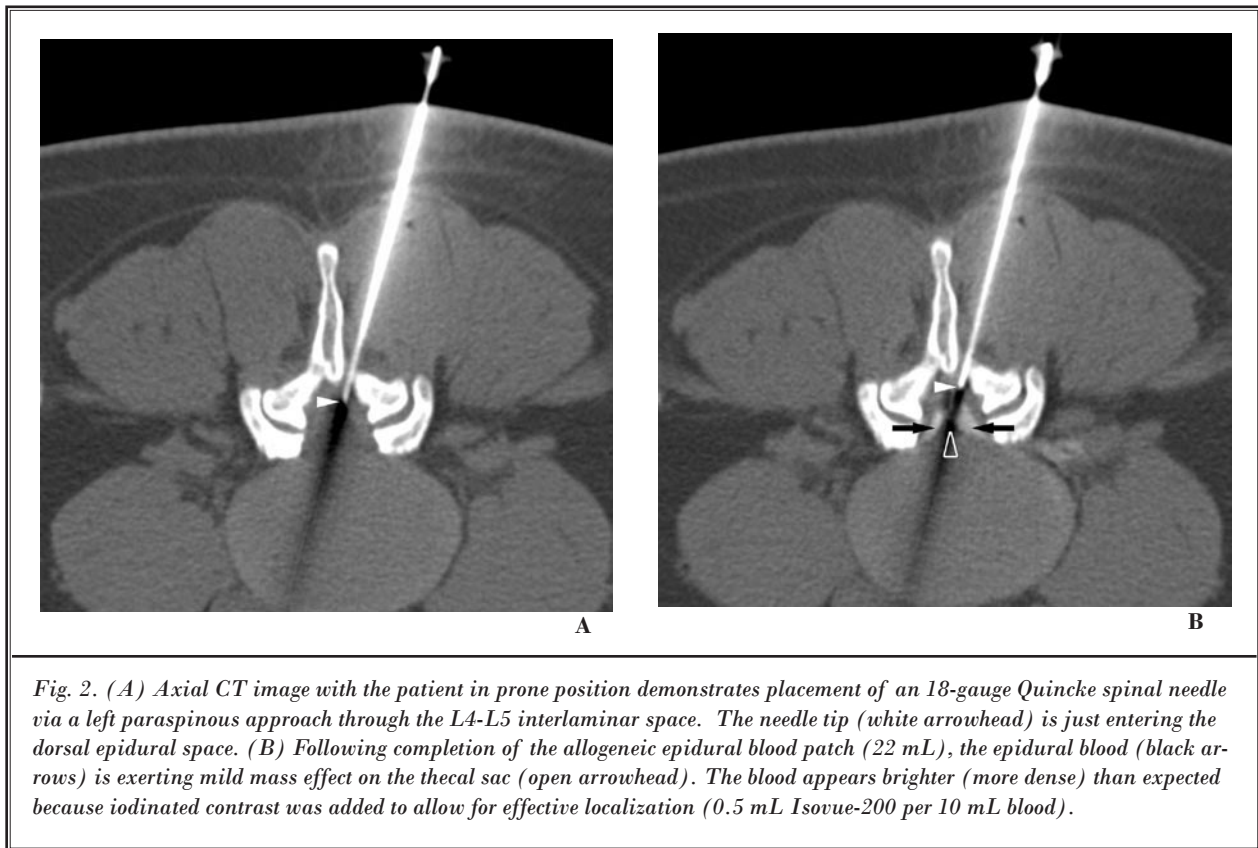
(A) Axial CT image with the patient in prone position demonstrates placement of an 18-gauge Quincke spinal needle via a left paraspinous approach through the L4-L5 interlaminar space. The needle tip (white arrowhead) is just entering the dorsal epidural space. (B) Following completion of the allogeneic epidural blood patch (22 mL), the epidural blood (black arrows) is exerting mild mass effect on the thecal sac (open arrowhead). The blood appears brighter (more dense) than expected because iodinated contrast was added to allow for effective localization (0.5 mL Isovue-200 per 10 mL blood).
